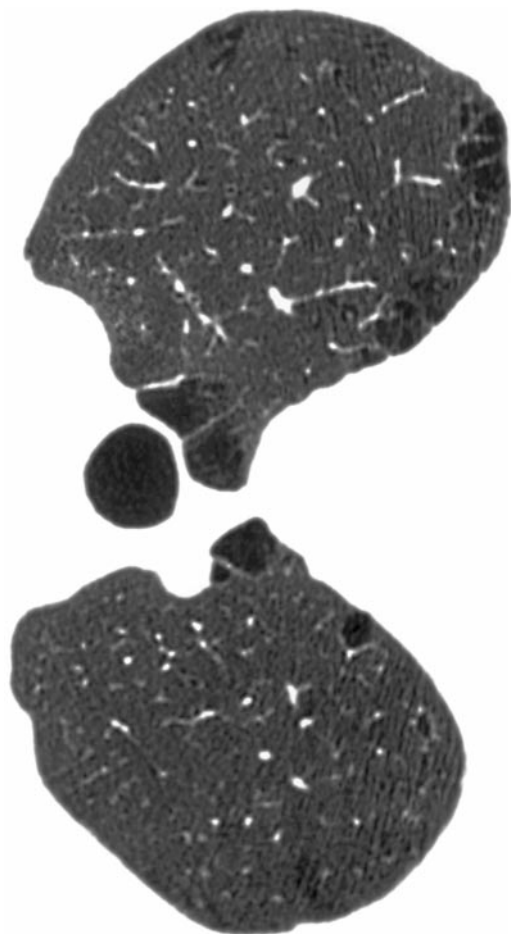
HRCT scan through the upper lung zones of the lung showing subpleural blebs.
